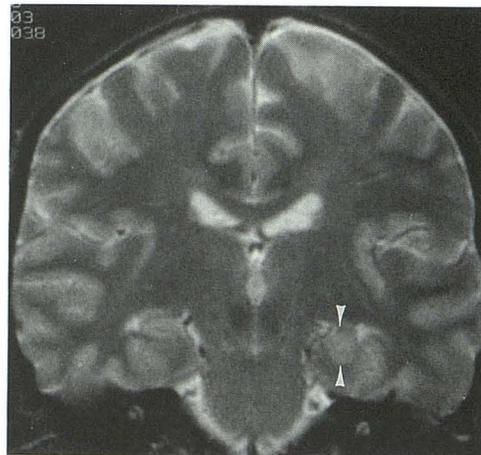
Thirty-one-year-old male control subject. T2-weighted image 2500/80. Note asymmetry between right and left hippocampi. Because left is globoid, one could question whether right has decreased volume. However, there is no signal abnormality, and collateral white matter is normal.
